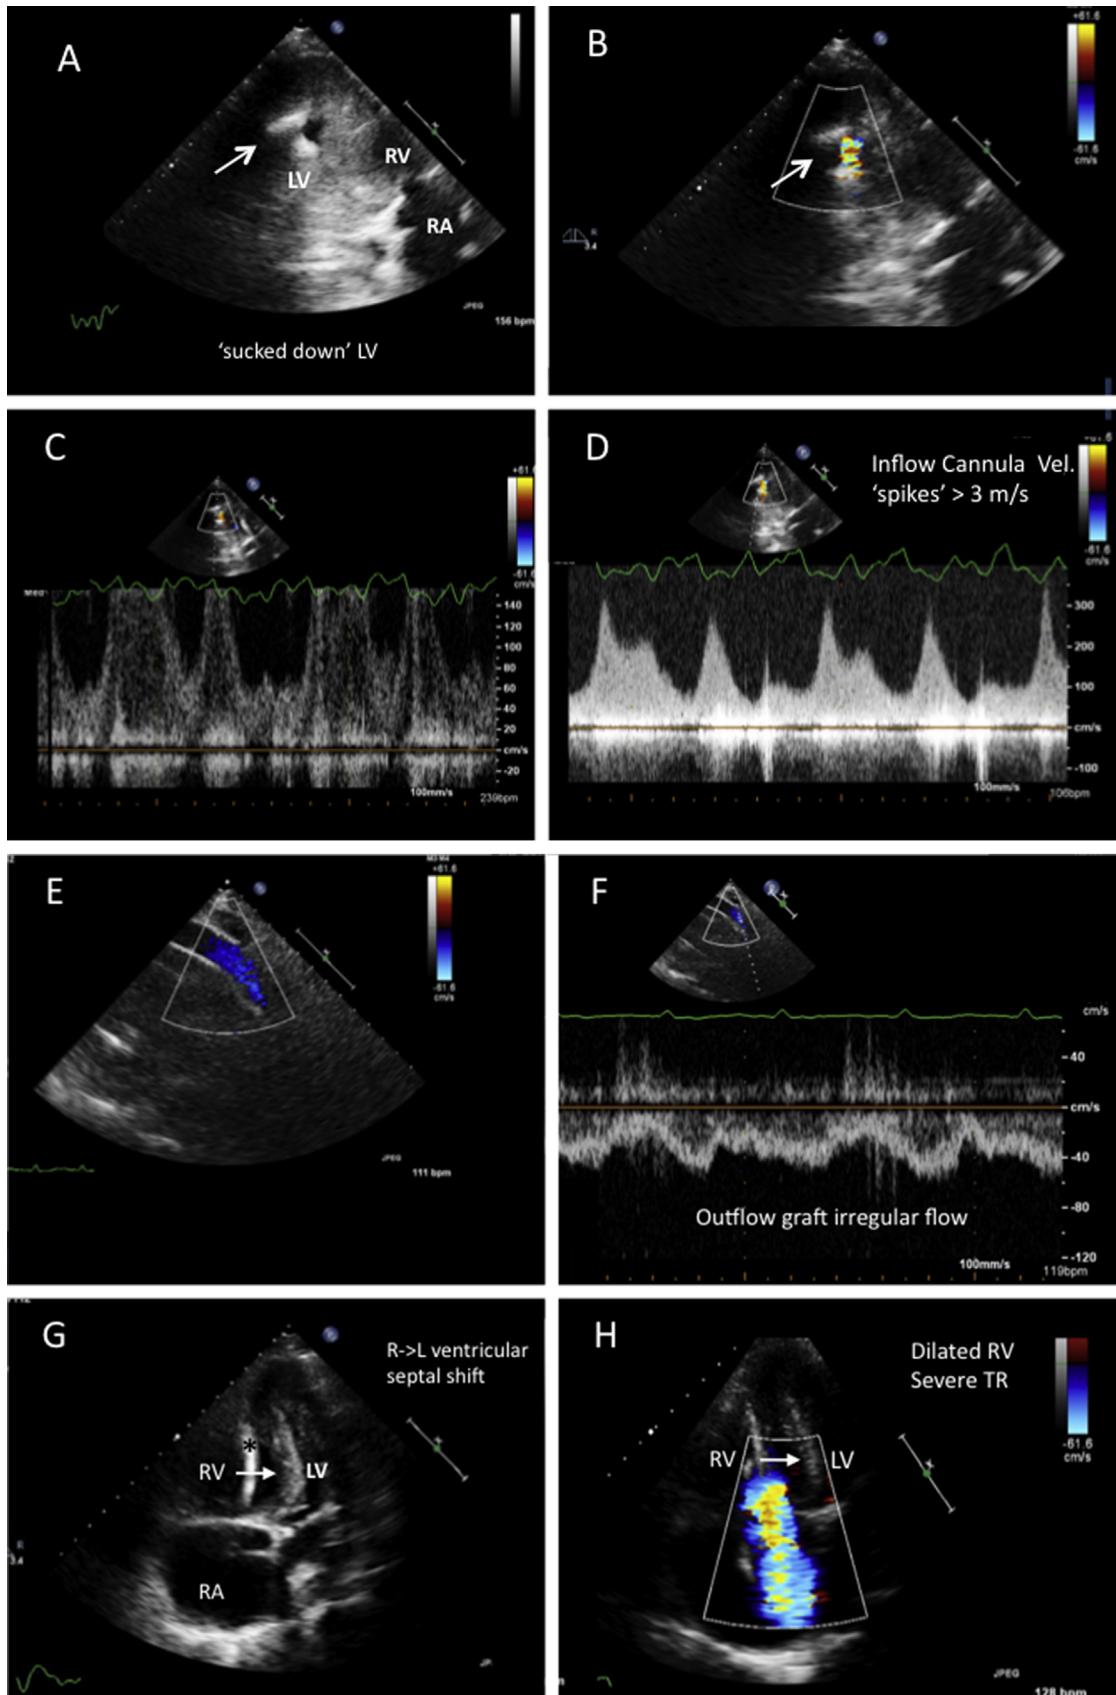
Suction event at a relatively low pump speed (HM-II, 8200 rpm) consistent with severe RV failure. (Because this condition was refractory to medical management, the patient received an RVAD after this exam). (A) Modified parasternal RV inflow-tract view. The tiny LV cavity is “sucked down” around the inflow cannula (arrow), and the ventricular septum is bowed towards the left. See also
